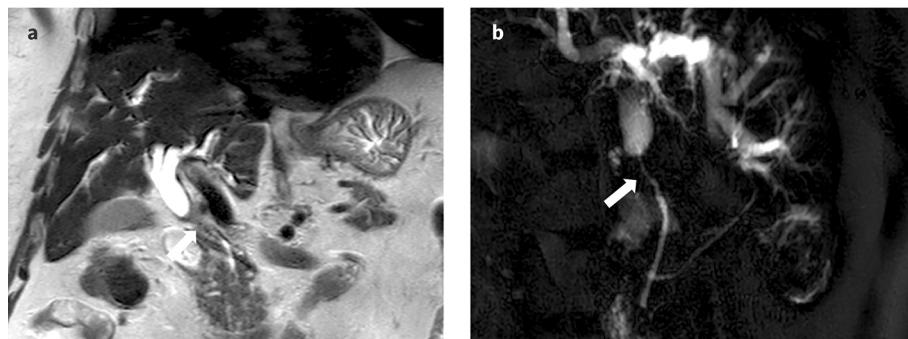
Cholangiocarcinoma. Long common bile duct stricture (arrow) without mass on MRI T2 W coronal sequence (a) and MR cholangiogram (b). Cytology brushings were negative but surgical resection revealed stage T2 cholangiocarcinoma.
